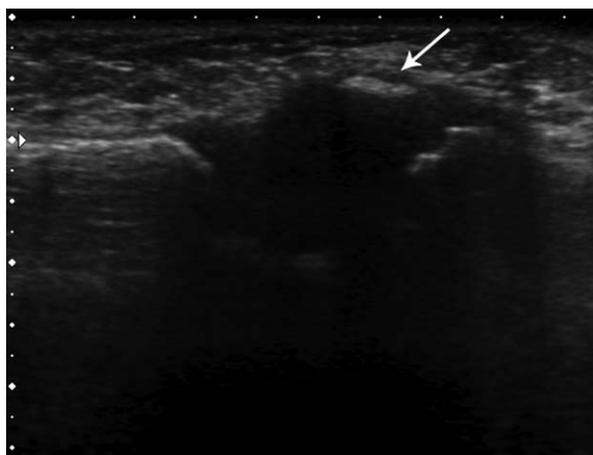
Follow-up US examination 2 years after initial presentation. Midline sagittal sonogram of the sternum shows the dislocated and partially ossified first sternal segment (arrow).
